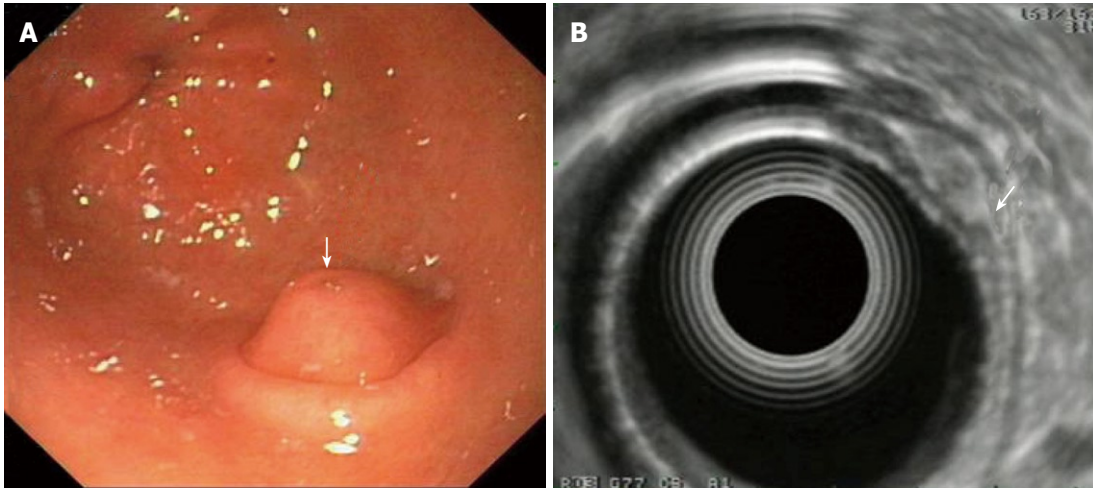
Pancreatic rest of the stomach: Endoscopic and endoscopic ultrasonography -imaging. A: Endoscopic image of a pancreatic rest. Note the duct opening on the surface of lesion is covered by a normal mucosa with a central umbilication (arrow); B: EUS imaging of the lesion which originates from the 3rd layer, i.e. the submucosa (arrow); note the lesion's mixed echogenicity. EUS: Endoscopic ultrasonography.
